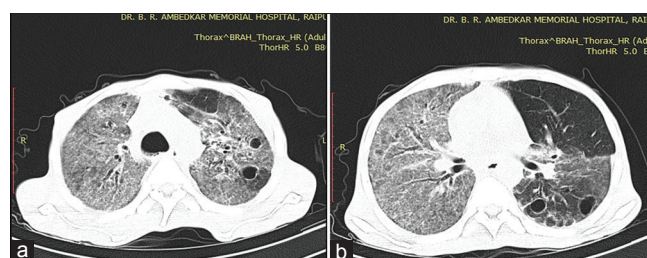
HRCT axial images (a) through the upper lobe (b) subcarinal level showing areas of crazy paving (ground-glass opacity with superimposed interlobular and intralobular septal thickening) and few small cystic lesion. Findings compatible with pneumocystis jiroveci pneumonia
